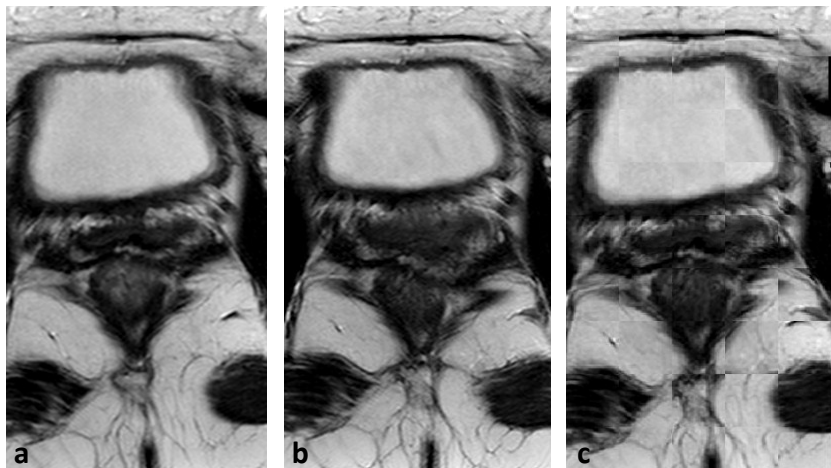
MR images of one subject, (a) Reference image (b) floating image (c) the checkerboard of the reference image and the deformed floating image using  $\alpha$ -MI\_pca-sift\_21.
